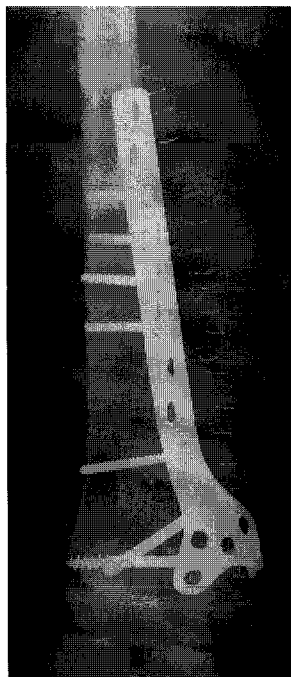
Immediate post-operative radiograph demonstrating geographic osteotomy and reconstruction with carefully fashioned allograft and plate and screws.*
